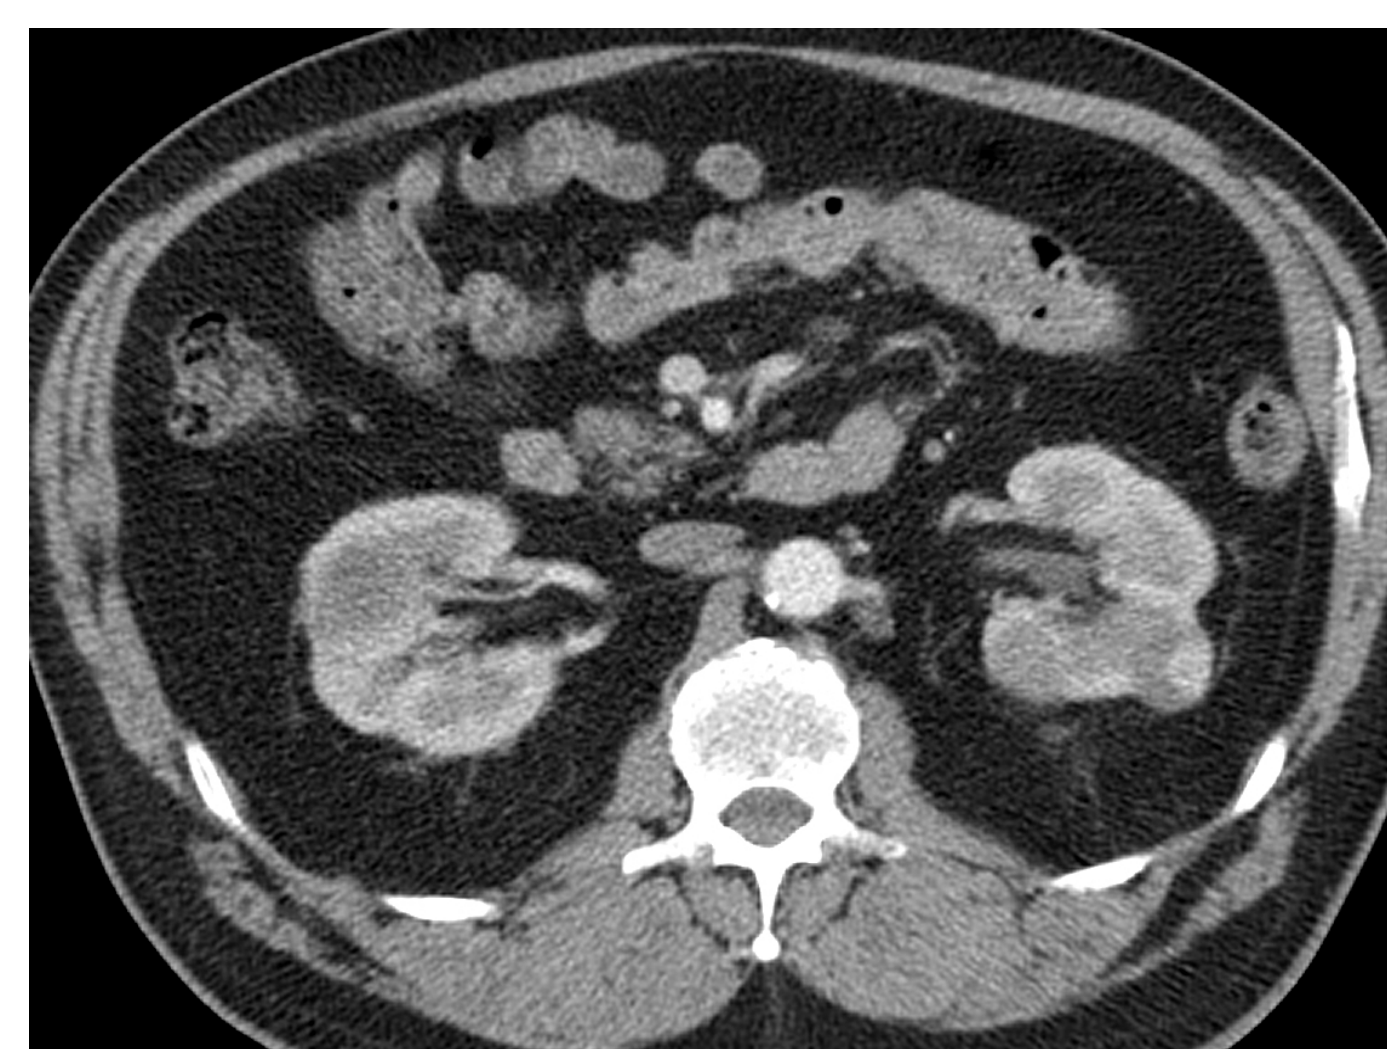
Axial contrast-enhanced preprocedural CT demonstrates a 3.1 cm enhancing mass at the mid pole of the left kidney.
